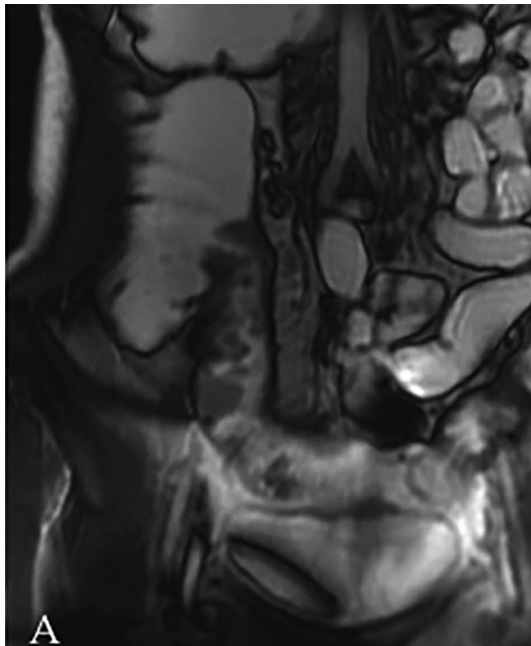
Pattern of fibrosis. A: Coronal T2-weighted image shows hypointense mural thickening of the last ileal loop; B: T1-weighted axial image after IV injection of contrast medium shows homogeneous attenuation of the intestinal wall.
